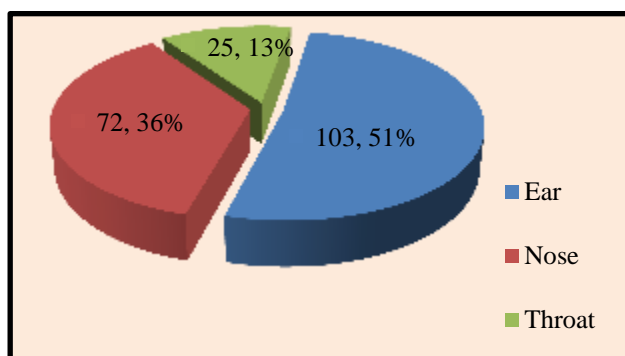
Case distribution.Figure 2: Foreign body in ear.Figure 3: Foreign body in nose.Figure 4: X-ray of neck- (AP, lateral view) showing radio-opaque circular FB in the cricopharynx at the level of C6-C7.
